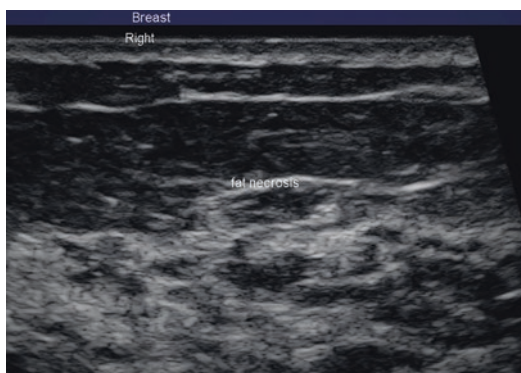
Grayscale ultrasound image of breast showing the diffuse hyperechoic areas with areas of relatively anechoic chambers representing a more liquid oil cyst
